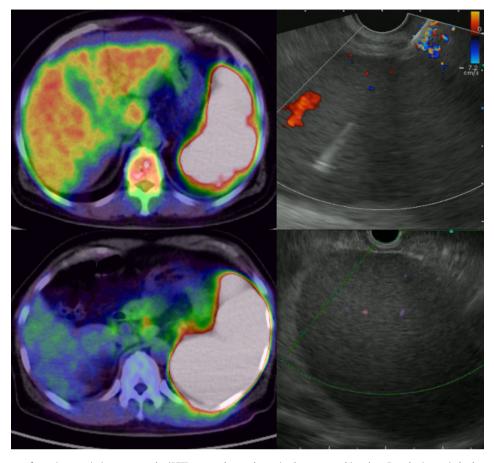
Cross-sectional images of a positron emission tomography (PET) scan and an endoscopic ultrasonographic colour Doppler image in both cases. Upper, case 1. Bottom, case 2. Left, PET scan demonstrating splenomegaly with intensive uptake. Right, endoscopic ultrasonographic image of an enlarged spleen in which a mass is never identified.
